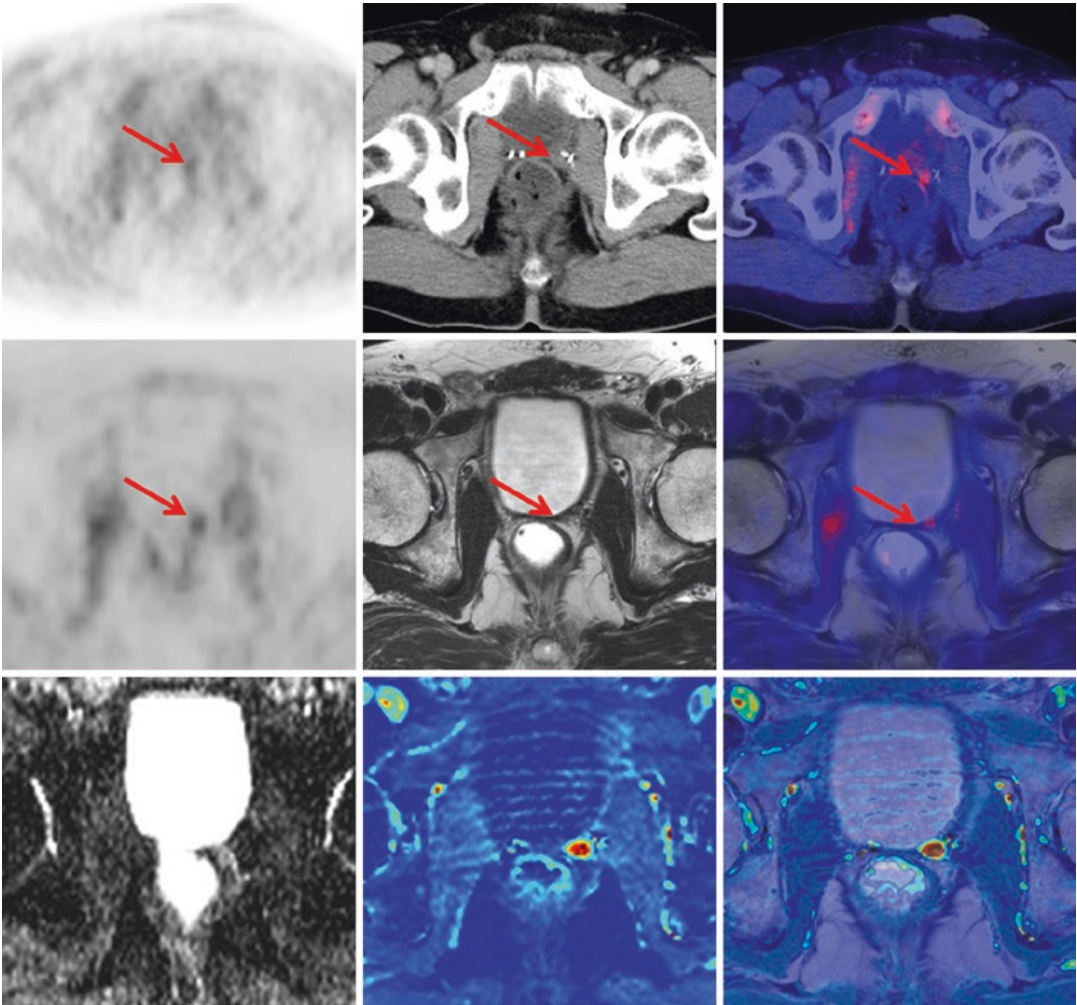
^{11}C -Choline PET/CT and PET/MR of a 79y/o patient with biochemical recurrence (PSA 1.7 ng/ml) after radical prostatectomy (*upper row*). PET/CT showed a faint choline uptake adjacent to the bladder on the left side which raised the suspicion for local recurrence but was judged as being unclear. PET/MR images demonstrated tracer uptake in a tiny tissue nodule (*middle row*).
